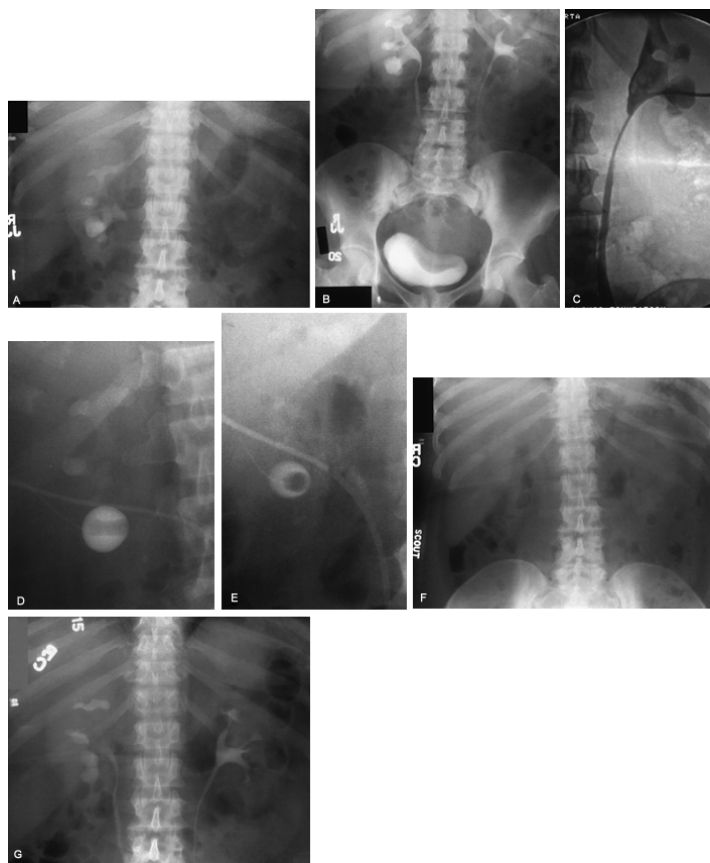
A: Plain film reveals a complete staghorn calculus filling the collecting system of the right kidney. B: Intravenous urography confirms an otherwise well-functioning kidney. Note that the kidney is “high riding” such that percutaneous access to the upper infundibulocalyceal portion of the stone would require access above the eleventh rib with subsequent risk of hydrothorax or pneumothorax. C: As an alternative, percutaneous debulking is performed via a lower infundibulocalix allowing access to the pelvic and lower infundibulocalyceal portions of the stone. D: Scout film from initial nephrostogram reveals mid and upper infundibulocalyceal fragments remaining that are inaccessible to rigid access via the lower-pole percutaneous tract. These inaccessible residual fragments are treated with shock wave lithotripsy. E: Twenty-four hours following shock wave lithotripsy, the previously inaccessible upper infundibulocalyceal fragments have migrated to the renal pelvis, where they are easily managed with second-look nephroscopy. F: Scout film from follow-up intravenous pyelogram 6 weeks later reveals no residual stone fragments. G: Following contrast injection, the kidney is seen to be well functioning.
